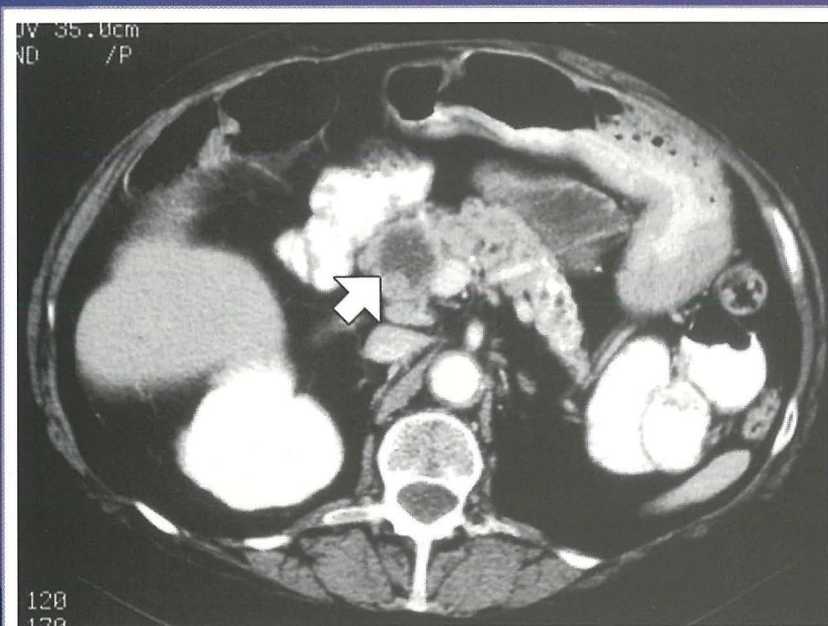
Chronic pancreatitis treated with a Puestow procedure, CT scan shows anastomosis of a dilated pancreatic duct with a jejunal loop mimicking a cystic pancreatic mass (arrow)
